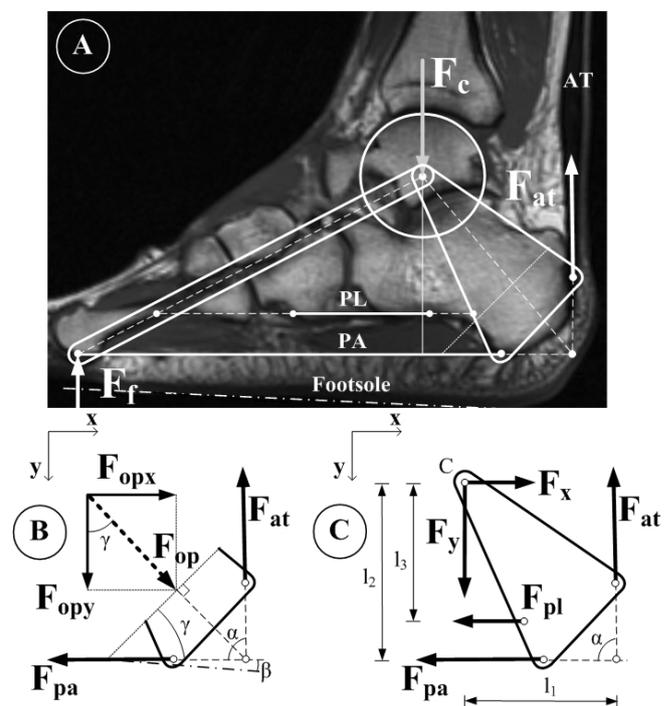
Sagittal T1-weighted MRI study of a foot that is modeled as a system of two trusses, at the apex connected by a hinge and stabilized by two wires representing the plantar aponeurosis (PA) and the long plantar ligament (PL). The ground reaction force at the forefoot (F_c) is balanced by the joint contact force (F_f) and the Achilles tendon (AT) force (F_{at}).
